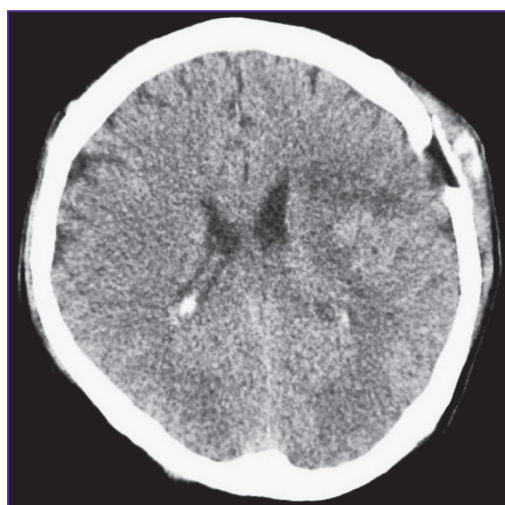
Post-operative computed tomogram of the male patient aged 49. Hemorrhagic substrate evacuation is almost complete. The Reperen plate tightly adjoins the bone defect margins
